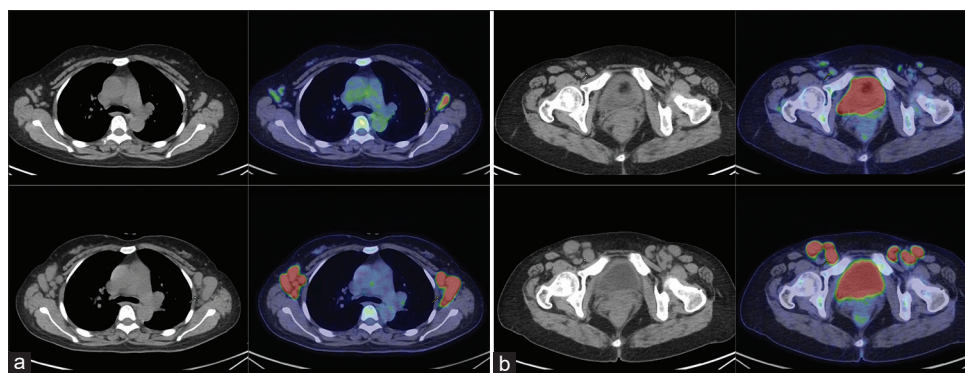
Transaxial computed tomography and positron emission tomography/computed tomography images showed the enlarged bilateral axillary (a) and inguinal (b) nodes in the first ^{18}F -fluorodeoxyglucose positron emission tomography/computed tomography
